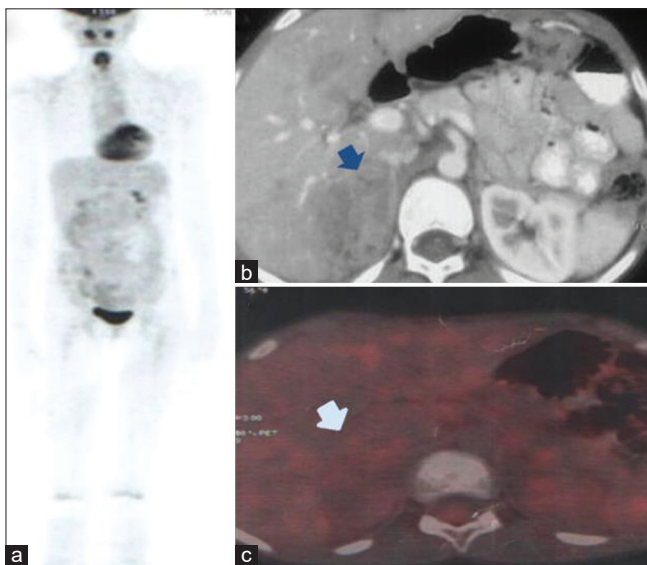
Maximum intensity projection image of ¹⁸F-FDG PET (a), cross-sectional early arterial phase image of CECT (b) and fused image (c) of ¹⁸F-FDG PET/CT of patient 31 with isolated right-sided pheochromocytoma (PCC). ¹⁸F-FDG PET/CT was done to rule out multifocal/ metastatic disease in this 19 years old; however, primary lesion itself was missed by ¹⁸F-FDG PET/CT
